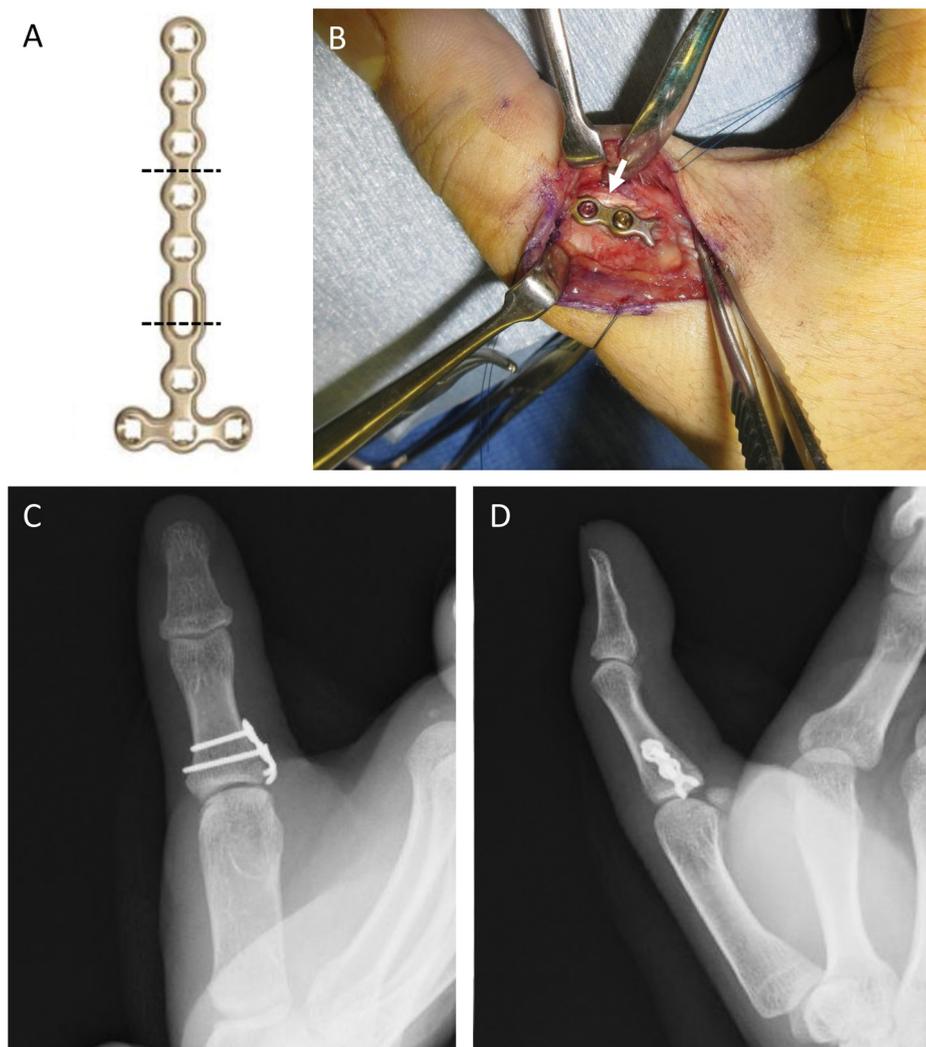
A. A two-hole mini hook plate is made by adapting a 1.5-mm VA locking T-plate. Importantly, the plate should be cut at the oblong hole of the plate to make a hook large enough to lift the avulsion fragment. B. Intraoperative picture of Case 1 after hook plate fixation. The arrow indicates the long fiber of the adductor pollicis tendon. C and D. Postoperative radiographs demonstrate anatomical reduction of the bone fragment.
